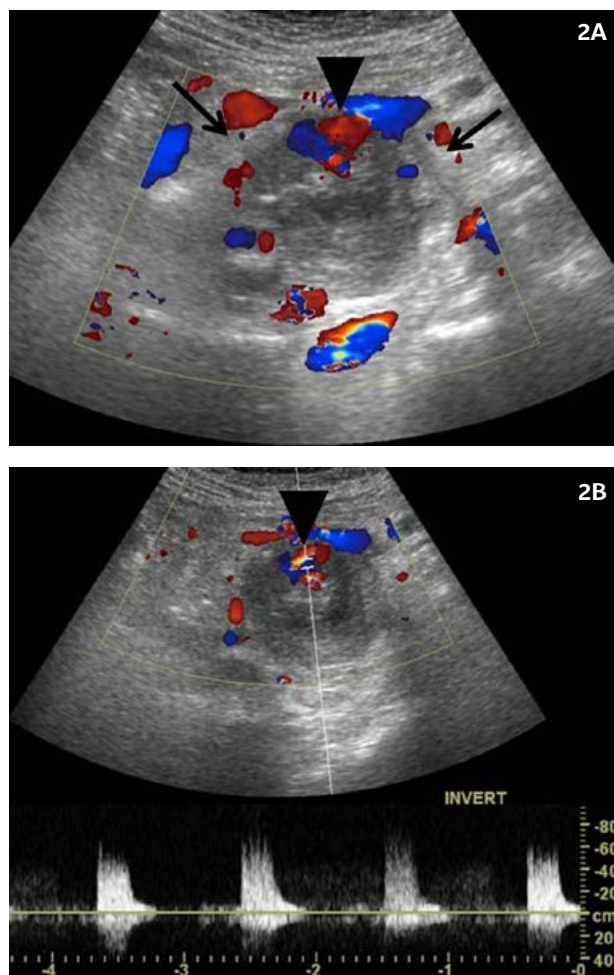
Color Doppler ultrasonography shows a heterogeneously hyperechoic pseudocyst of about 4cm at the pancreas head and an anechoic sac located at the anterior portion of the pseudocyst wall. The typical swirling signal called "yin-yang" sign is seen in the sac (arrowhead).
